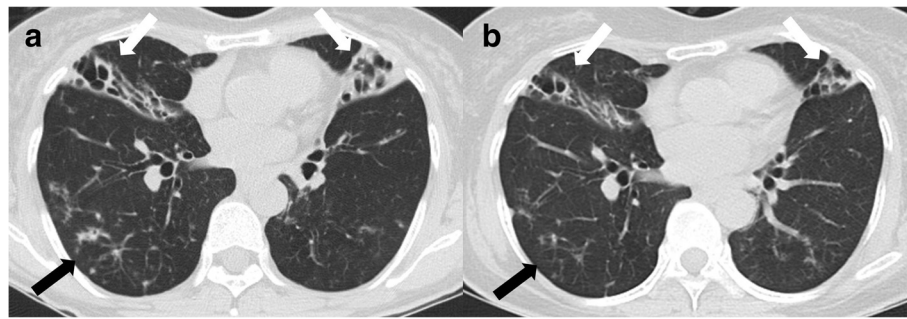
A 62-year-old female with bronchiectasis and nontuberculous mycobacterial lung disease caused by *Mycobacterium abscessus* subsp. *abscessus*. a Transverse chest computed tomography scan (2.5-mm-section thickness) at the start treatment revealed bilateral bronchiectasis and consolidations (white arrows) in the right middle lobe and lingular division of the left upper lobe as well as multiple tree-in-bud appearances (black arrow), suggesting bronchiolitis. b Transverse chest computed tomography scan (2.5-mm-section thickness) at 12 months of antibiotic treatment revealed decreased consolidation around the bronchiectasis (white arrows) and decreased bronchiolitis (black arrow)
